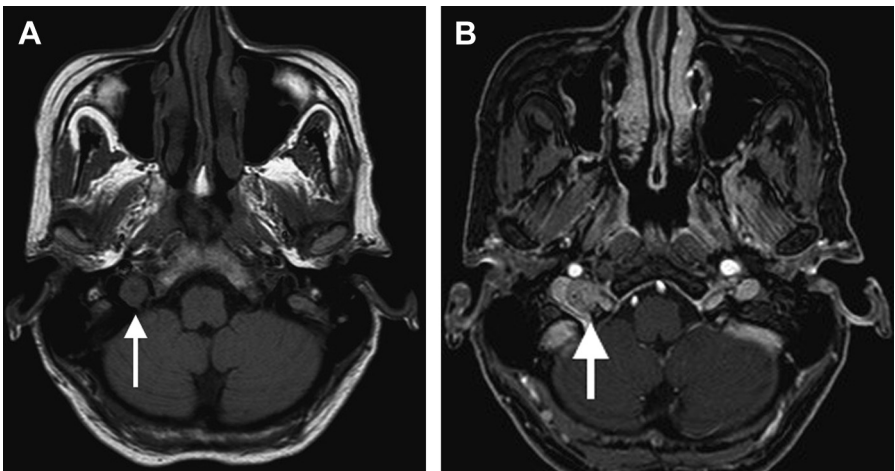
(A) Axial cut of a T1 MRI without contrast showing a right jugular foramen schwannoma. The tumor is designated by the white arrow. (B) Axial cut of a T1 MRI with contrast showing enhancement of a right jugular foramen schwannoma. The tumor is designated by the white arrow.
